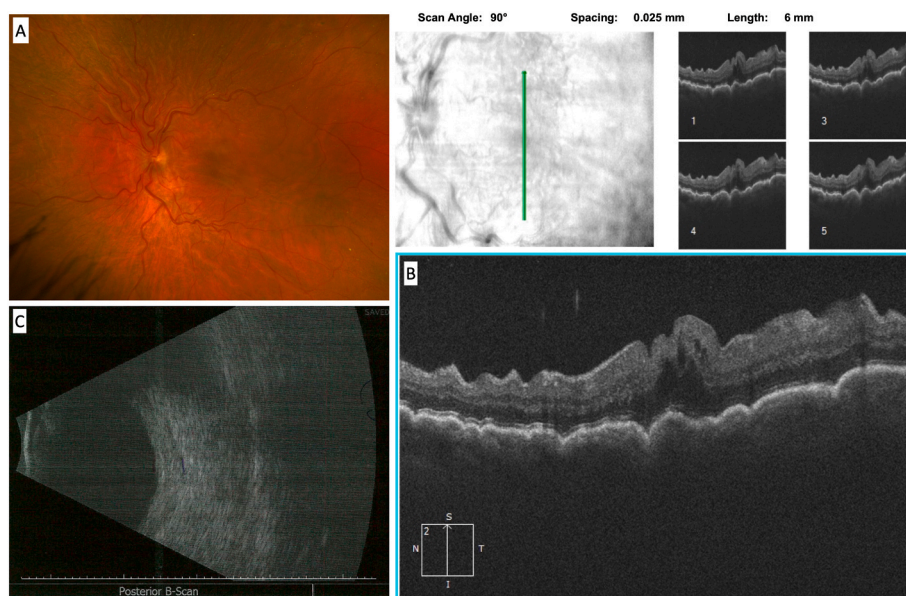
Left eye imaging at presentation: (A) color fundus photography showing choroidal folds and dilated, tortuous veins; (B) macular optical coherence tomography showing choroidal folds; (C) B-scan ultrasound showing thickening of the posterior sclera. (For interpretation of the references to color in this figure legend, the reader is referred to the Web version of this article.)
